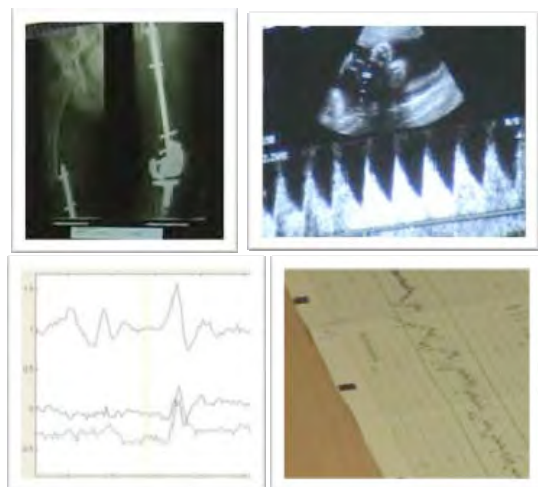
Top row, an x-ray of a leg and an ultrasound image and the flow in the umbilical cord of the fetus. Bottom row, accelerometer data of an elderly woman trying to answer the phone while using a walker and a cardiotocography of the fetus of a pregnant woman with diabetes.
